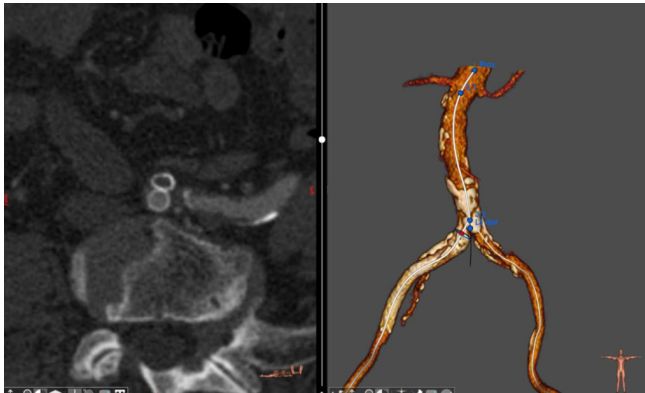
6-month post-operative CT scan demonstrating patent iliac stents with preserved true lumen flow
